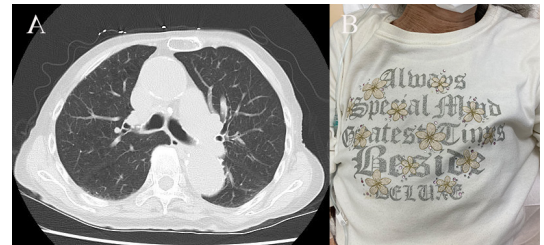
(A) CT of the chest showed a calcified ascending and descending aorta, but no pulmonary nodules on the lungs. However, beads from the patient's shirt appear as multiple nodules. (B) Photograph shows shirt with beads.
